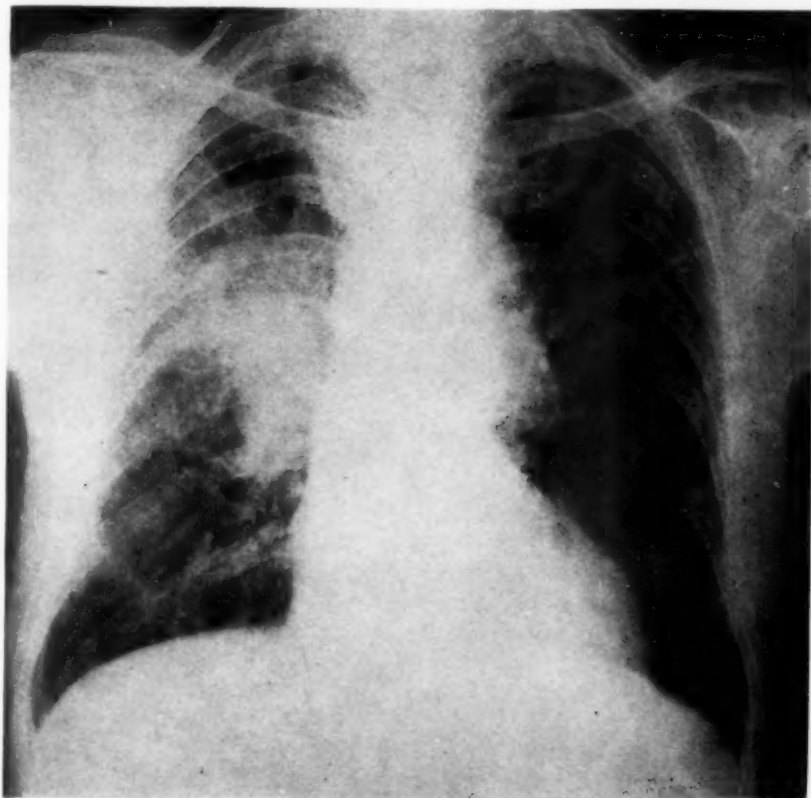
Initial roentgenogram. Note the dense infiltration of the right midlung field, with strand-like projections radiating toward the pleura.
